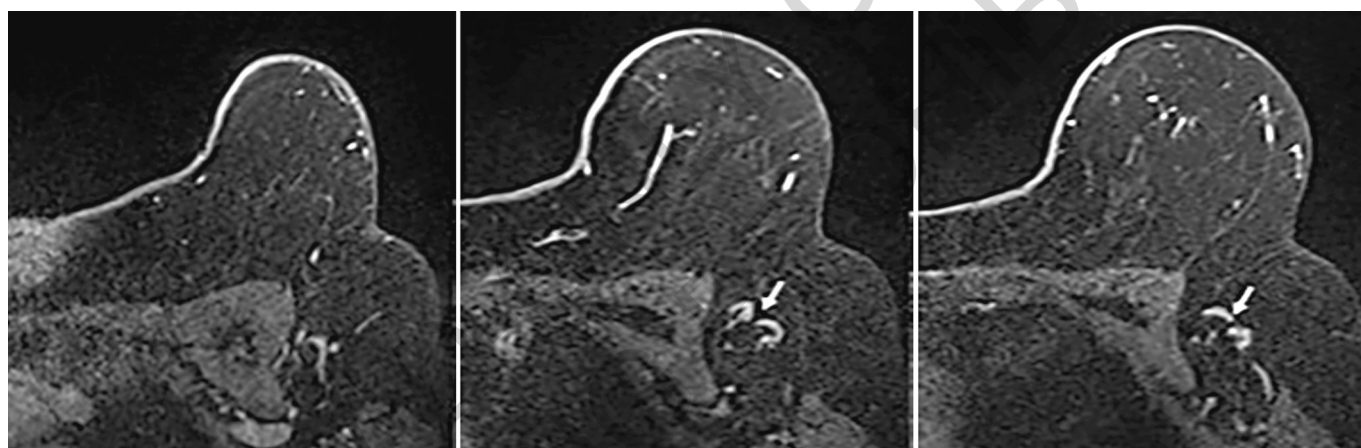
Magnetic resonance imaging (MRI) of breast. Axillary lymph nodes were normal in the preoperative staging MRI examination of a 61-year-old patient diagnosed with estrogen receptor (+), progesterone receptor (+), Human Epidermal Growth Factor Receptor-2 (-), grade I invasive ductal carcinoma detected by routine screening in the left breast. Sentinel lymph node biopsy was positive and axillary dissection was performed. Metastasis was detected in two of 16 lymph nodes. T1 weighted images with axial post-contrast fat suppression showed oval-shaped lymph nodes with fat hilus and evaluated normally (arrows in 2b and 2c).
